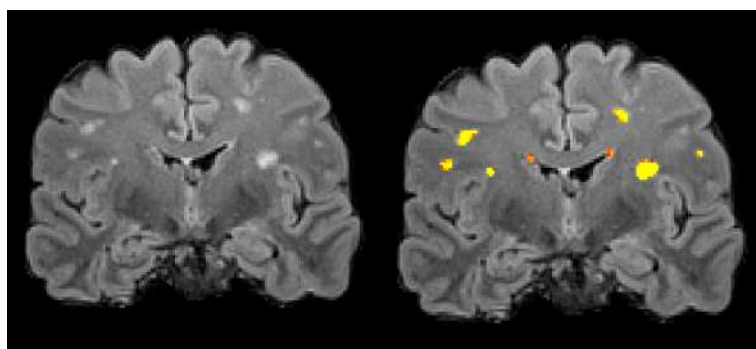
Example of the application and thresholding of the BIANCA lesion probability map. On the left it is shown a coronal slice of the T2-weighted FLAIR image and on the right, the same slice with application of the lesion mask (in yellow).
